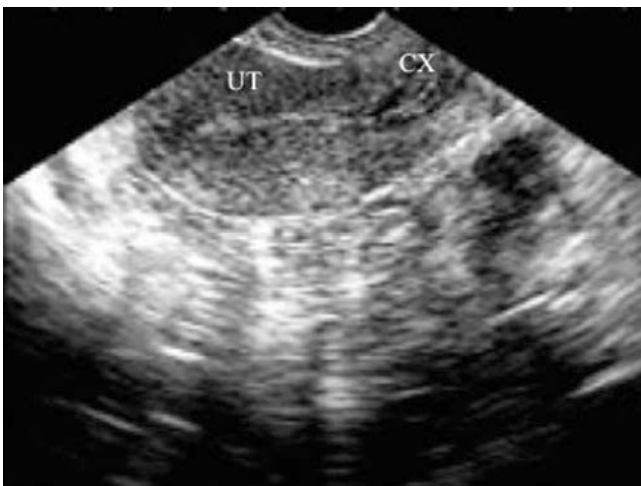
Early stage of hyperplasia. Sonogram shows the endometrium as a thin hyperechoic line
